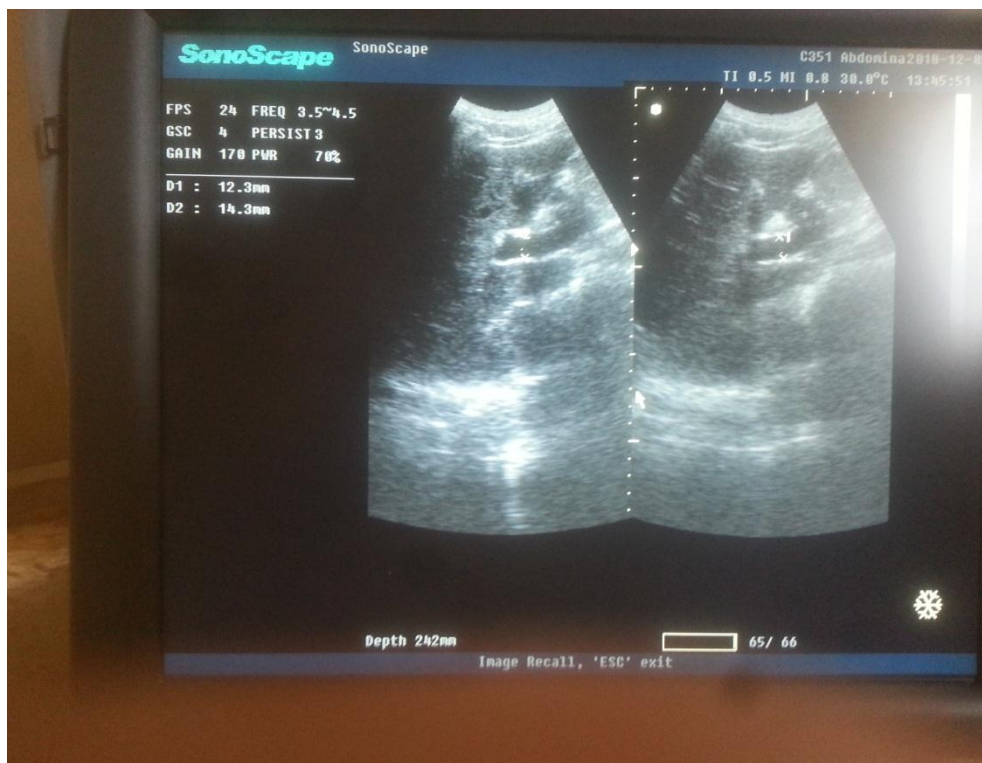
Fig (a-6): sonogram of liver female 47 years old with dilated PV in portal hypertension due to schistosomiasis
